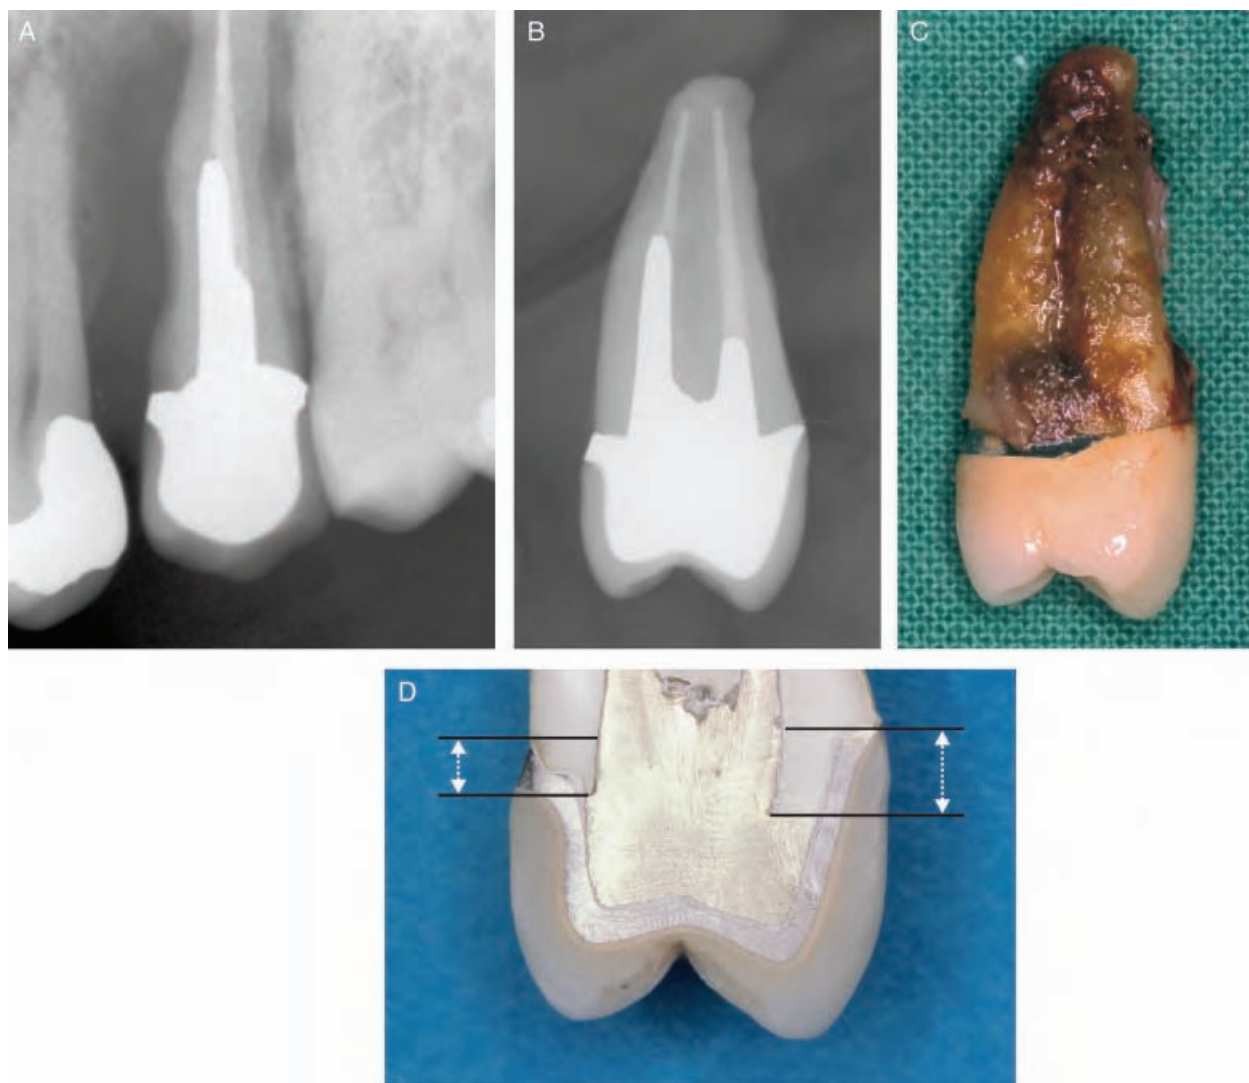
The maxillary second premolar of a 50-year-old patient had been treated endodontically ca. 10 years before, and restored with a cast post and a ceramo-metallic crown. The patient did not return to the clinic for any follow-ups until 10 years later when an abscess had emerged in the area. A radiograph demonstrated severe periodontal tissue destruction and the tooth was deemed non-treatable (A). Radiograph of the tooth after extraction (B) indicates that all treatments performed were carried out properly: an endodontic treatment with an adequately tapered canal preparation and dense root filling to the correct apical level; a cast post of adequate length, extending mainly in the palatal canal; good precision of the crown, and correct profiles. The mesial view of the tooth shows calculus and plaque covering the entire root surface to the apex (C). In order to examine the different components of the restoration, the extracted tooth was ground down in a bucco-lingual plan (D). The crown ends buccally on a 90° shoulder, and on a bevelled shoulder lingually, grabbing a sufficient quantity of residual tooth substance satisfying the ferrule effect. Consequently, this tooth was not lost because of endodontic or reconstructive failure, but for periodontal disease.
